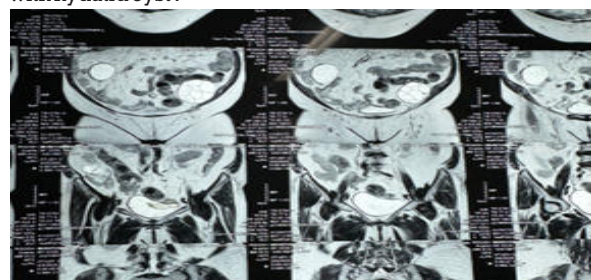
MRI Image Showing Active Hydatid Cyst.
